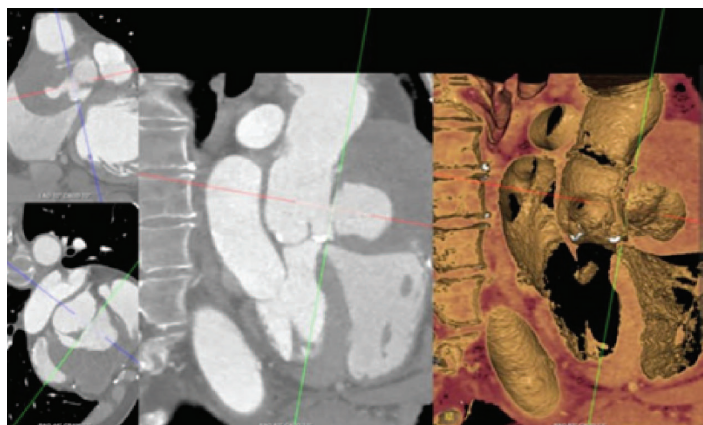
CT reconstruction of the aortic root pseudoaneurysm before (upper image) and 6 months after the intervention (bottom image)
